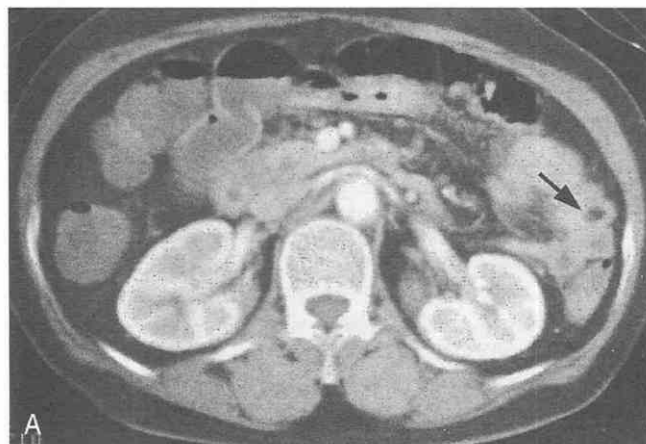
Multiple lipomas in the small intestine. A and B, CT scan shows multiple lipomas (arrows) in the small-bowel loops.
